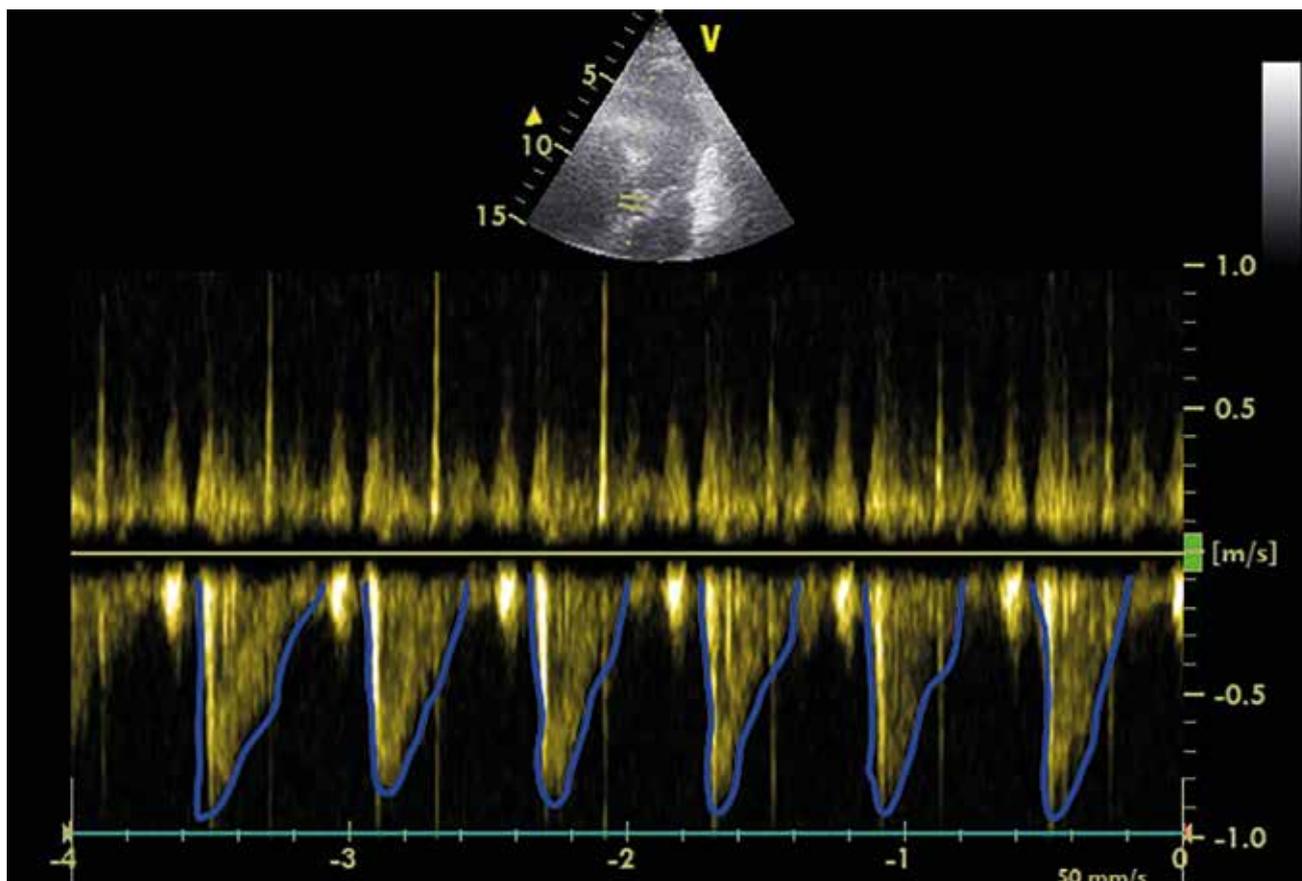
Pulse-wave Doppler and correct selection of downward sloping curves is shown
